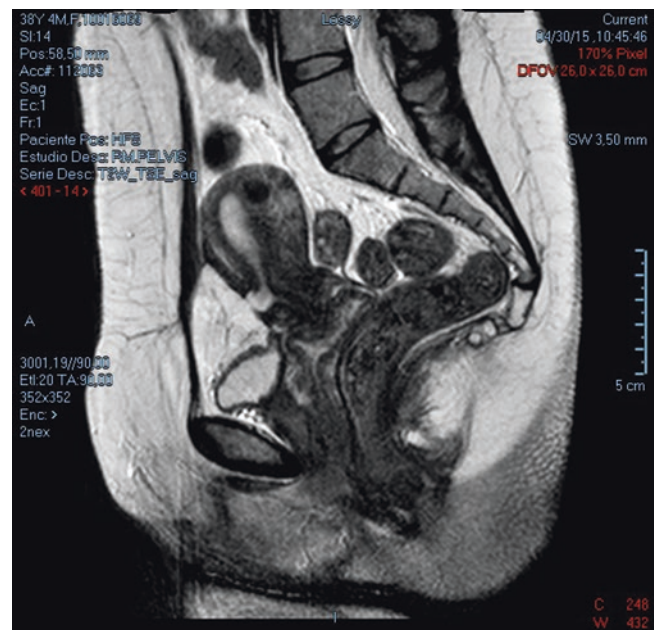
Visualization of the defect with MRI
